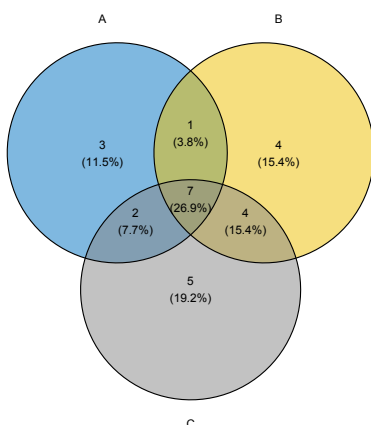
Number and overlaps of abnormal exams (A = MRI, B = CSF, C = EEG)
